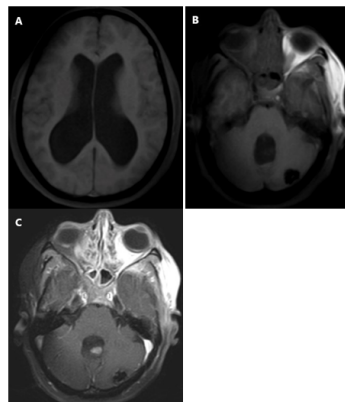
MRI a & b) T1 fat suppression & c) T1 fat suppression Post contrast (Gd): -a & b) Shows complete suppression of fatty component
